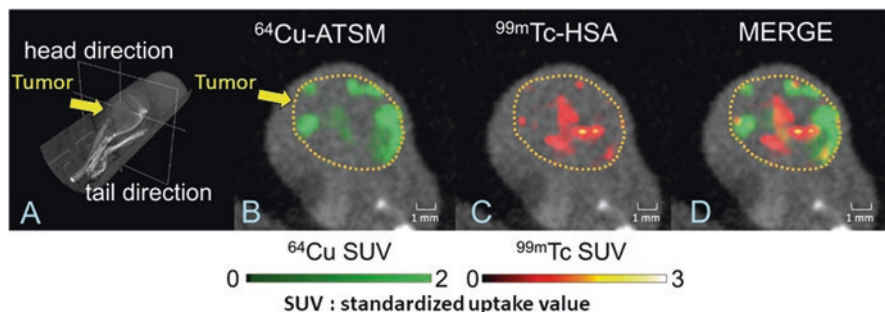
In vivo SPECT/PET/CT imaging with ^{64}Cu -ATSM and $^{99\text{m}}\text{Tc}$ -HSA
